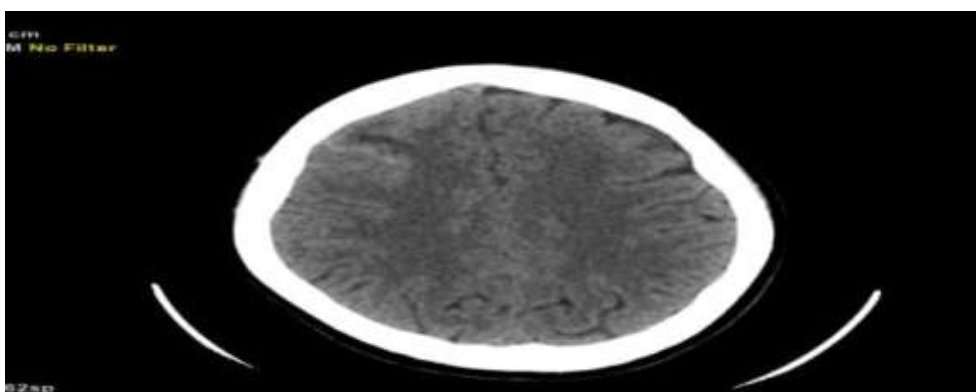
Axial non-contrast CT scan of the brain shows hyperdense sulcal spaces along the right frontal convexity, suggestive of acute subarachnoid hemorrhage.
